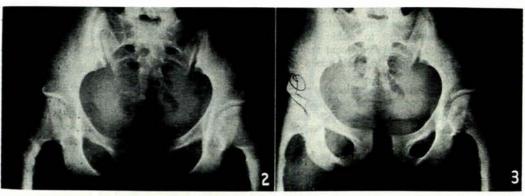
Post-symphysiotomy radiograph in the erect position, with patient standing on both legs. Fig. 3. Post-symphysiotomy radiograph in the erect position, with patient standing on one leg.
